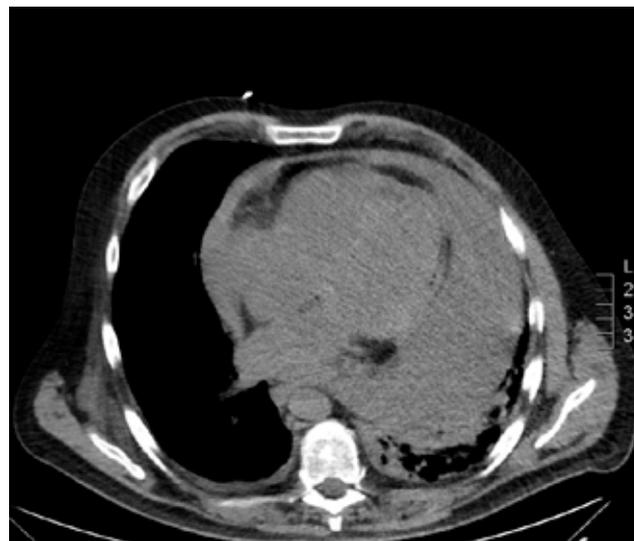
CT scan showing a large pericardial effusion
